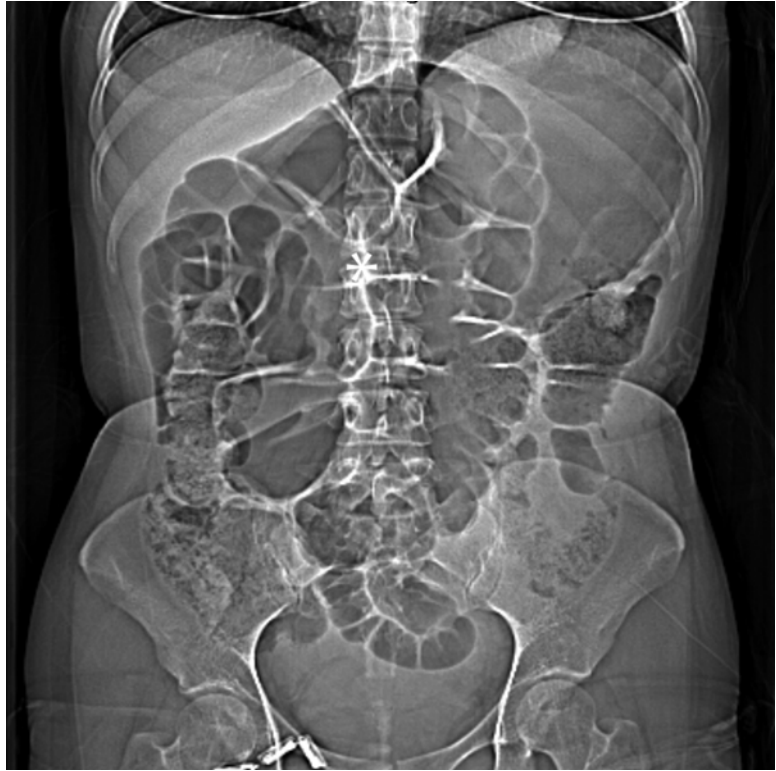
Sigmoid volvulus. CT topogram with * indicates classic coffee bean appearance
